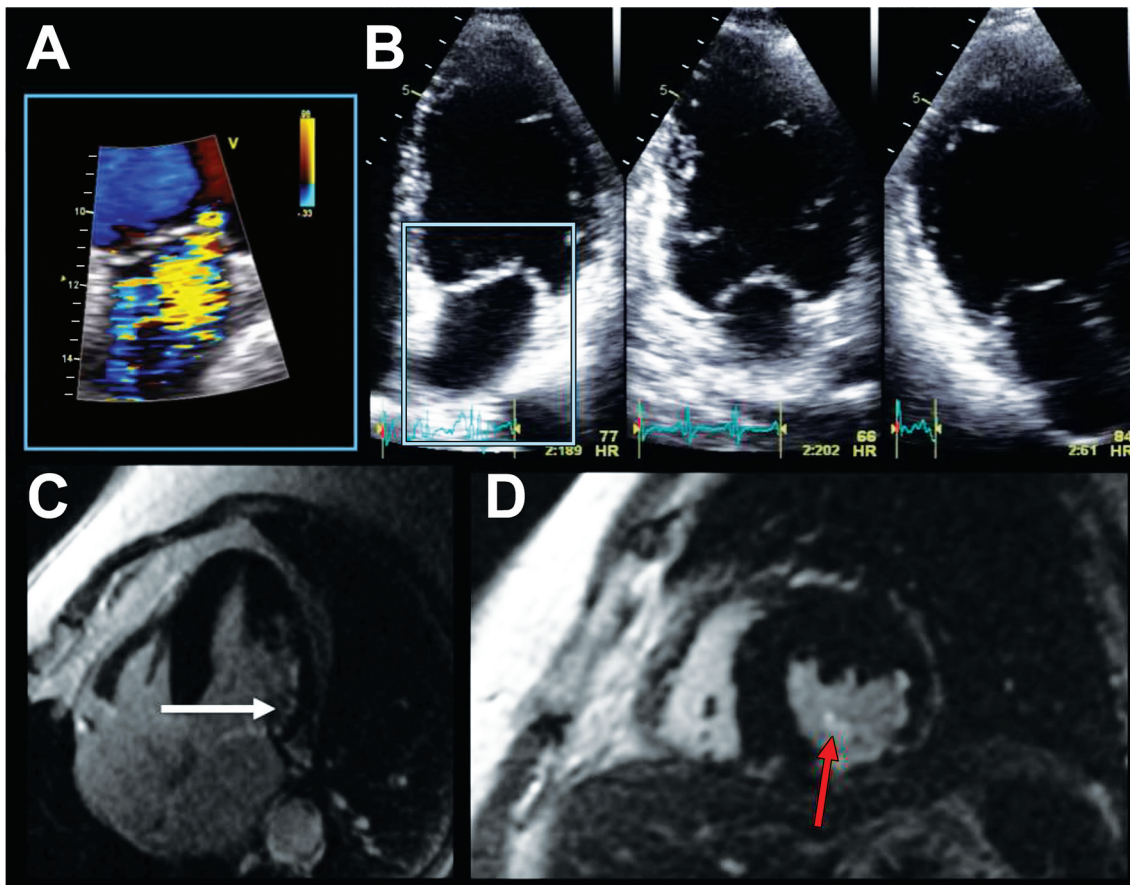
Moderate/severe mitral regurgitation by effective regurgitant orifice area (30 mm) is found in a patient with inferolateral myocardial infarction without left ventricular dilatation (A, B). Cardiac magnetic resonance images show (C) subendocardial late gadolinium enhancement (white arrow) in the inferior and inferolateral walls and (D) late gadolinium enhancement of inferomedial papillary muscle (red arrow).
